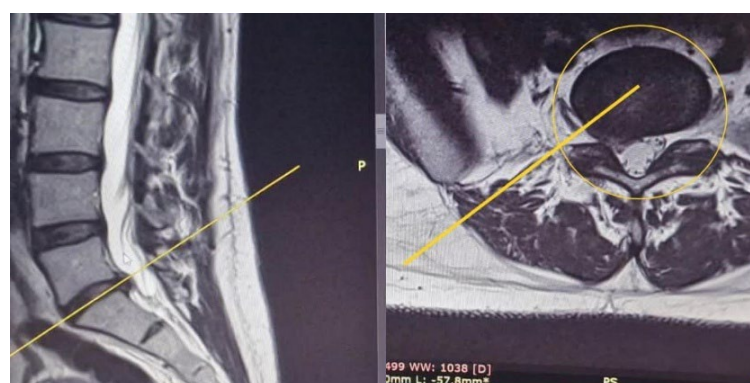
MRI imaging result of the first scan performed on 13.12.2022, at the neurologist's recommendation.
